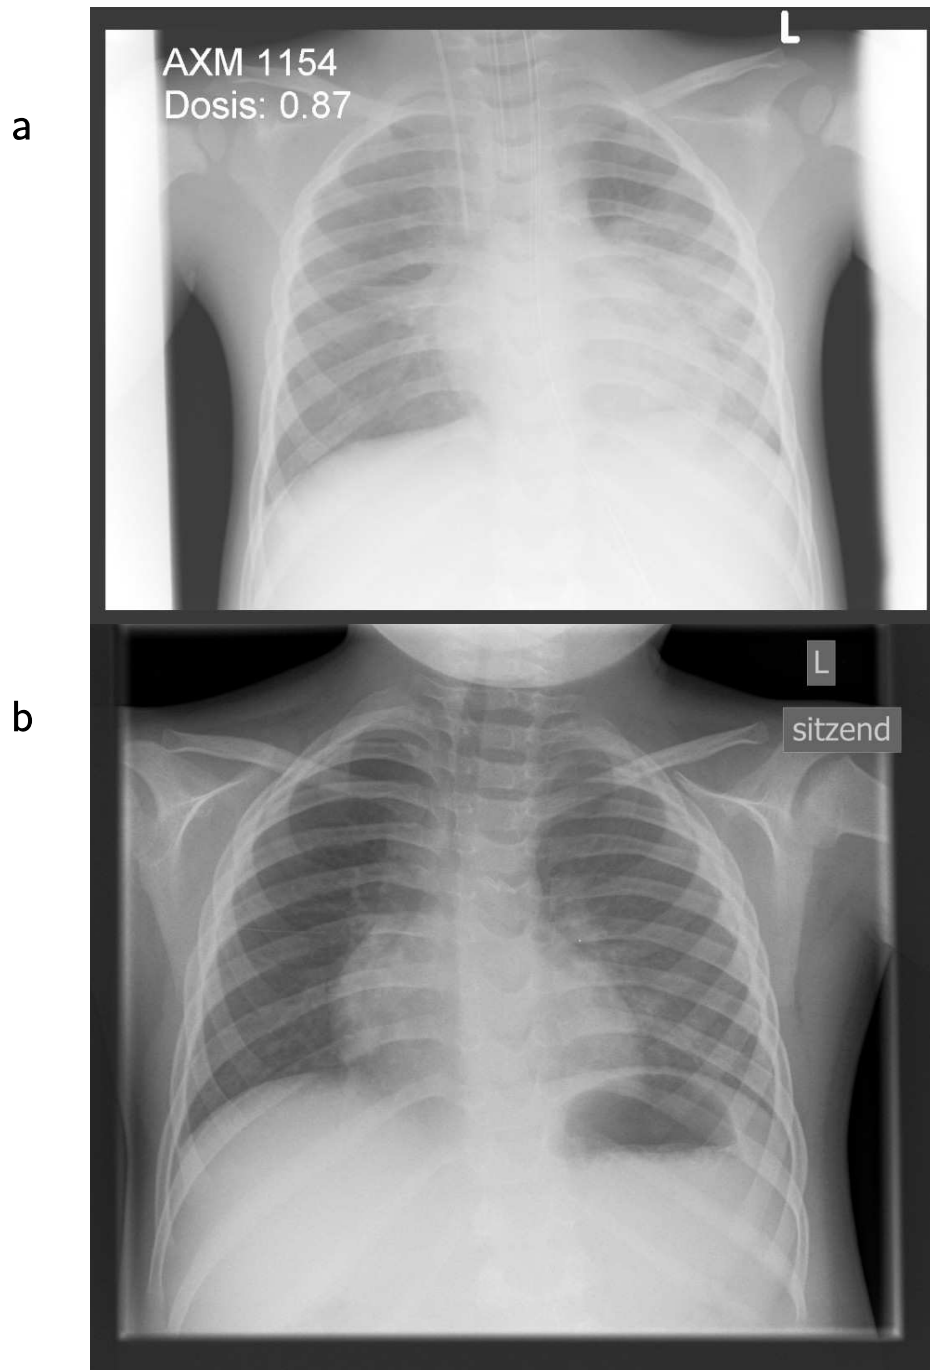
(a) chest X-ray from the 9th day of treatment with bilateral shadowing, (b) chest X-ray from the 20th day of treatment showing regressive reduction in transparency in the middle and lower lobes and complete regression of shading in the apical right middle lobe.
